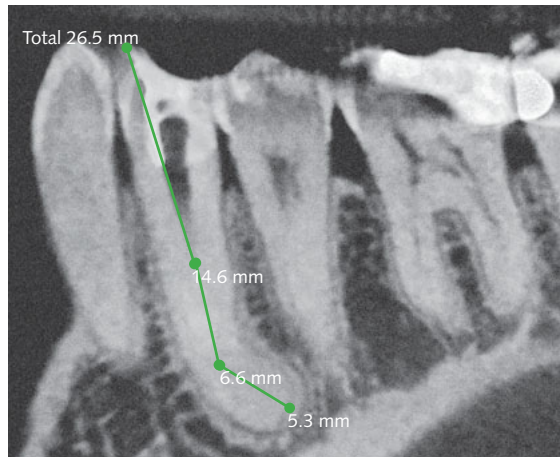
CBCT image. In a coronal section, the length of the tooth was measured from the buccal cusp to the root apex and was 26.5 mm.
